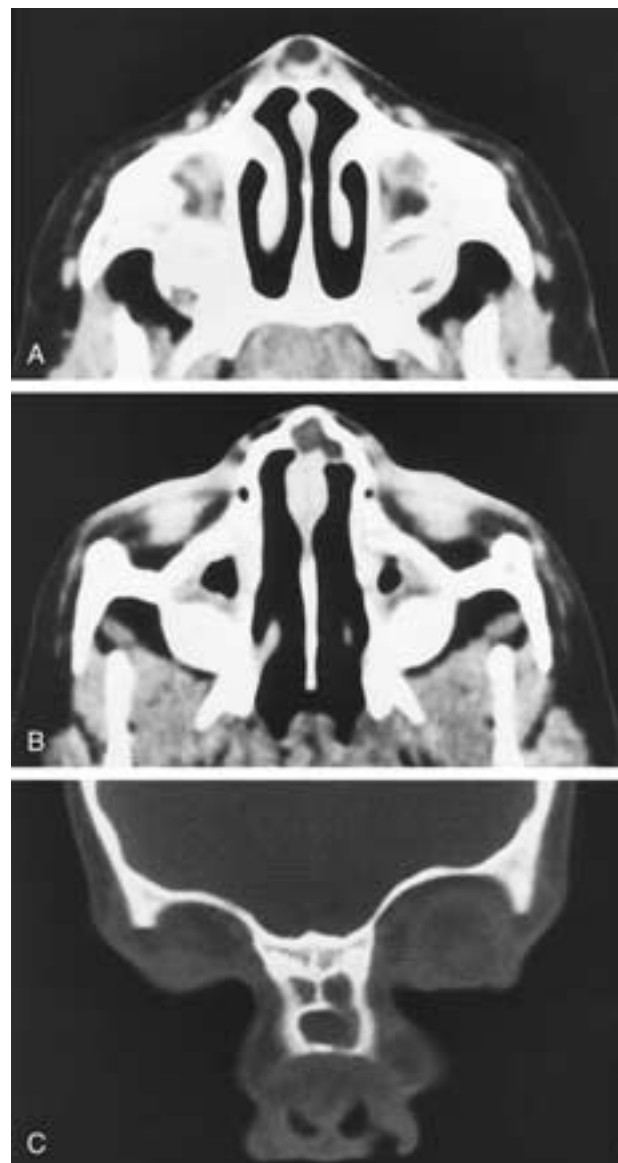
Mixed extranasal-intranasal dermoid with infection. A and B, Axial noncontrast CT demonstrates an extranasal (A) and an intranasal (B) mass, scalloped erosion of the nasal bones, and edema of the fat planes surrounding the cyst. C, Direct coronal CT shows the broadening and erosion of the nasal bridge.
